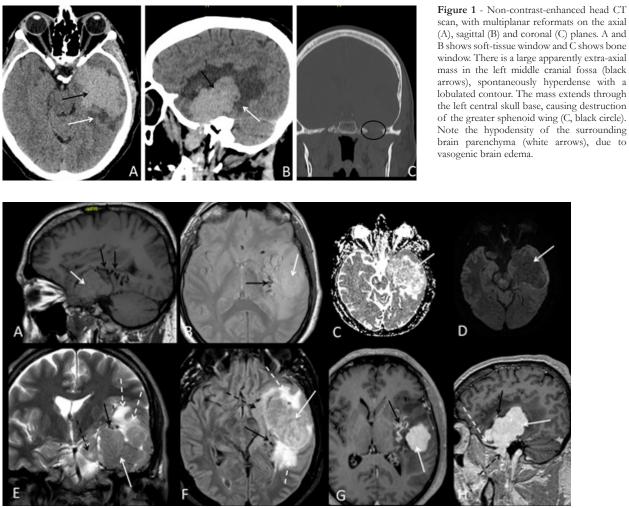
Contrast-enhanced MR study. The lesion (white arrows) is discreetly hyperintense on sagittal T1-weighted images (A) and isointense to gray matter on axial Proton-density-weighted: PDW (B) images. On coronal T2-weighted images (E) and axial Fluid-attenuated inversion recovery: FLAIR (F) images, the lesion (white arrows) is isointense to gray matter. Note the extensive vascular flow voids surrounding the lesion (black arrows). There is mass effect with a rightward tilt of the mesencephalon, effacement of the ambiens cistern and inferior uncal herniation (E and F, black dashed arrows). The surrounding brain parenchyma reveals high signal intensity (E and F, white dashed arrows) due to vasogenic edema. On Diffusion-weighted imaging: DWI the lesion shows high ADC values (C, white arrow) and low signal intensity on b1000 (D, white arrow). Axial (G) and coronal (H) contrast-enhanced fat-suppressed T1-weighted images reveal intense and homogeneous enhancement (white arrows). The inferior extension to the infratemporal fossa and the surrounding (H, white dashed arrow).
